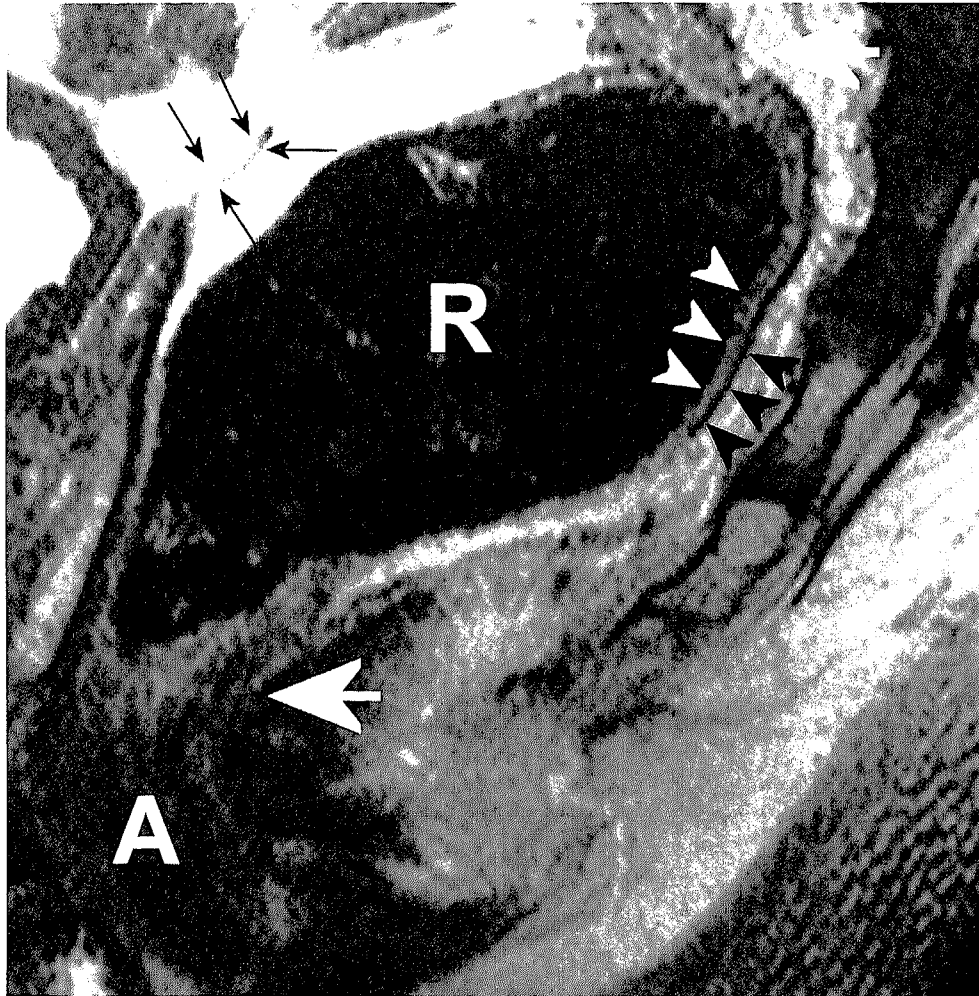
Sagittal T2W FSE (TR/TE 4598/150 msec) MR image of a healthy male volunteer shows the rectosigmoid transition and end of the rectum (white arrows) in the anal canal (A). The rectal ampulla (R) is evident. The inner layer of the rectal wall can be visualized as a line of intermediate signal intensity relative to muscle tissue representing the mucosa (white arrowheads). The outside layer of the rectal wall, a hypo-intense line, corresponds to the muscularis propria recti (black arrowheads). The peritoneal reflection appears as a low signal intensity V-shaped structure ("seagull sign", black arrows).
